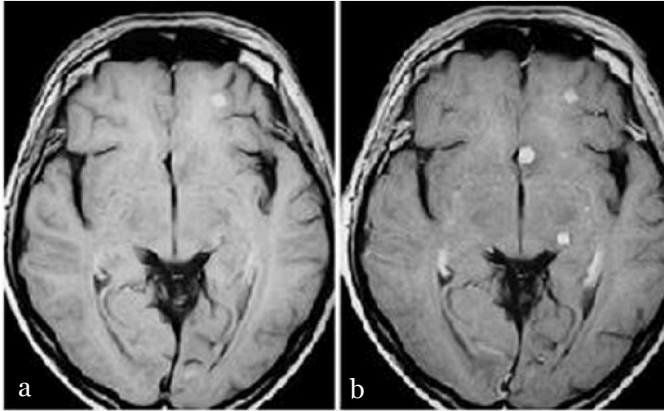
Contrast-enhanced MRI in a patient with cerebral metastasis. Increasing the amount of contrast material from a single dose (a) to triple dose (b) substantially increased the number of visible cerebral metastases.
